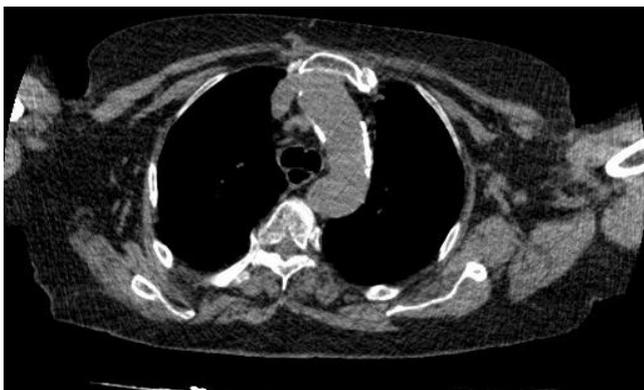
Postoperative CT image
